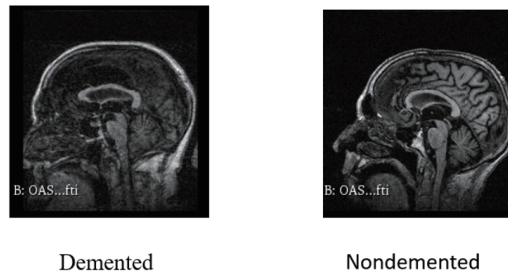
Magnetic resonance images from OASIS-2 data set.
